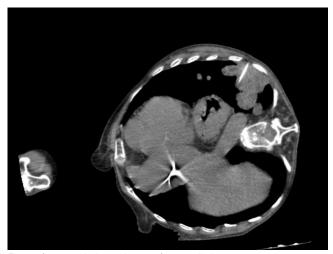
CT-guided transthoracic fine needle biopsy
